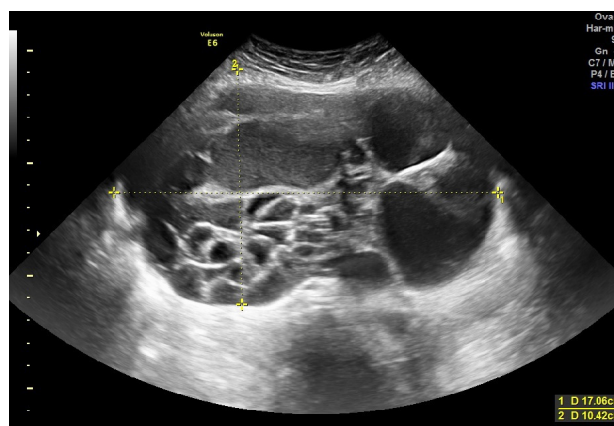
Ultrasound image demonstrates a multilocular, cystic, smooth tumour with thin-walled partitions with the largest dimension of 17 cm in the projection of the left adnexa
